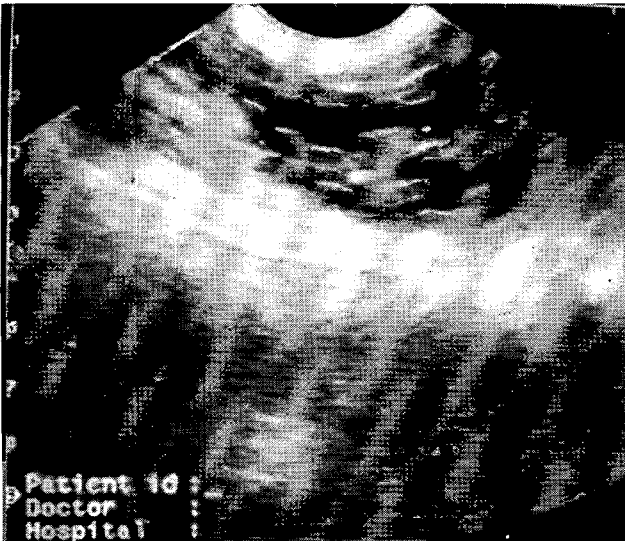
Small and hyperechoic appearances of a kidney with loss of normal architecture and thinning of cortex in ultrasonography.
